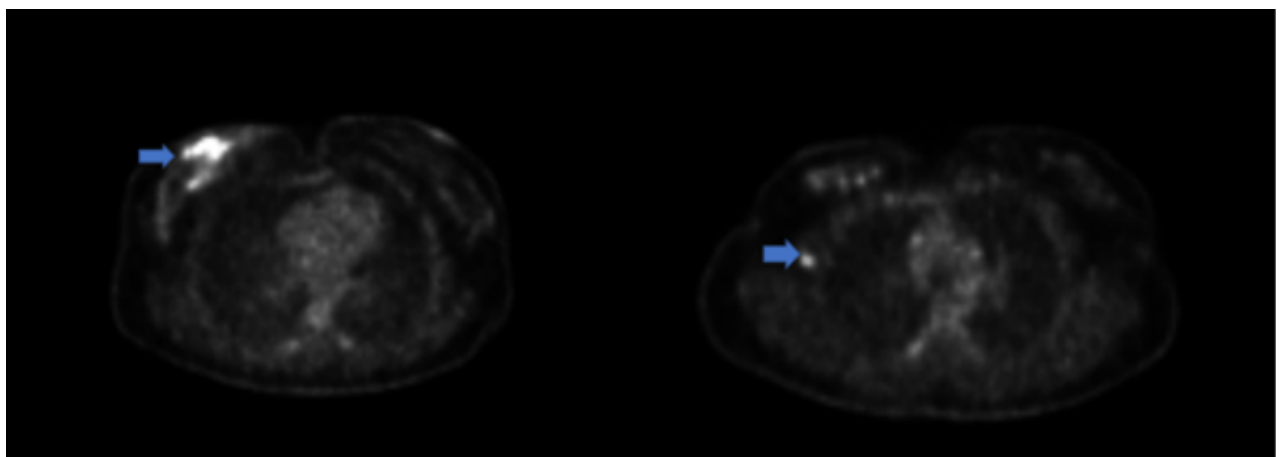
Hypermetabolic nodular area covering the upper middle zone of the right breast on 18F-FDG PET/CT images, with no significant mass formation. Additionally, a hypermetabolic axillary lymph node is observed, which is indicative of a primary malignant breast tumor (arrows).
